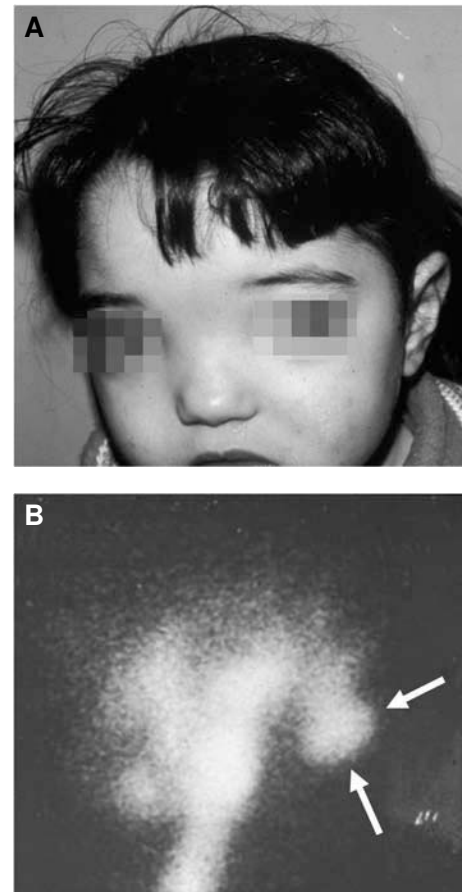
A. Note the severe hypertelorism in a girl with meningoencephalocele.⁹ B. The malformation (arrows) is clearly observed in the technetium 99m scintigraphy.
